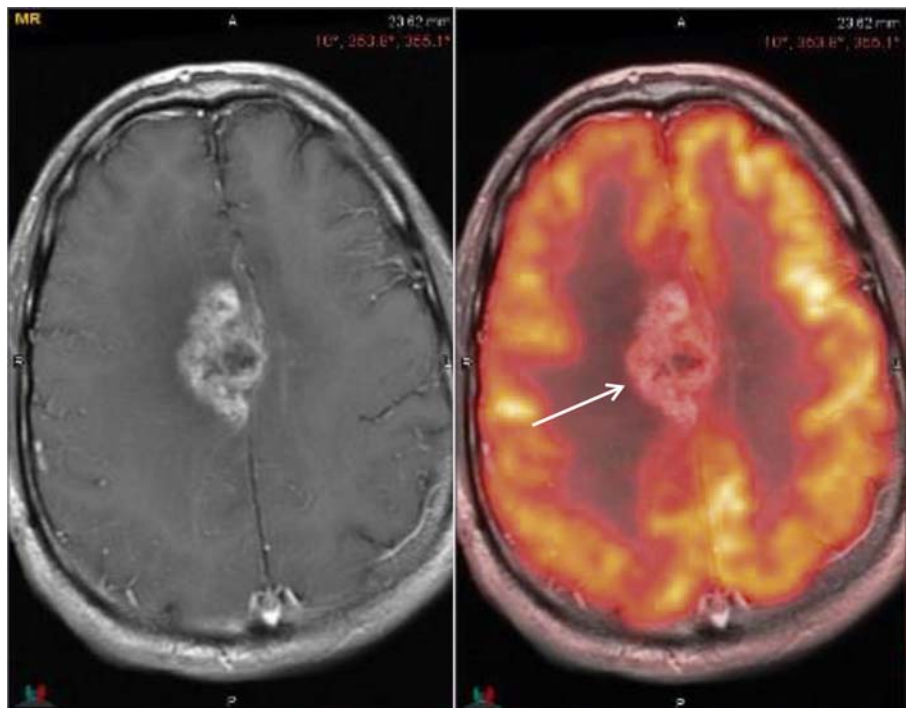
PET/MRI of recurrent high grade glioma. *Arrow* points toward areas of increased uptake of radioactive label suggesting active disease.
